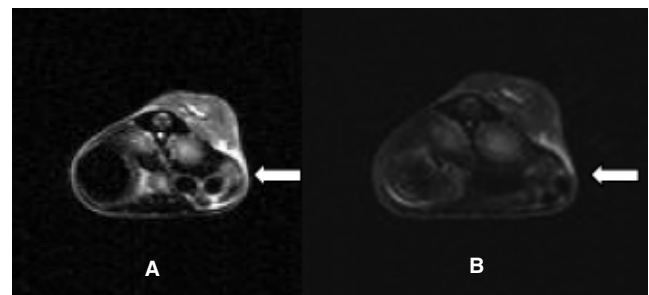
Indirect tumor targeting in D430B subcutaneous lymphoma. On T2-weighted images, before (A) and after (B) USPIO-anti-biotin administration. There was a nonhomogeneous decrease in signal.
